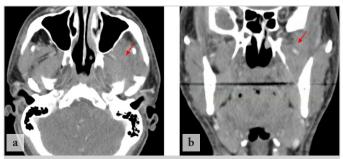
CT scans post-operation: a. Axial CT view showing complete resolution of the infratemporal fossa abscess. b. Coronal CT view showing complete resolution of the infratemporal fossa abscess
